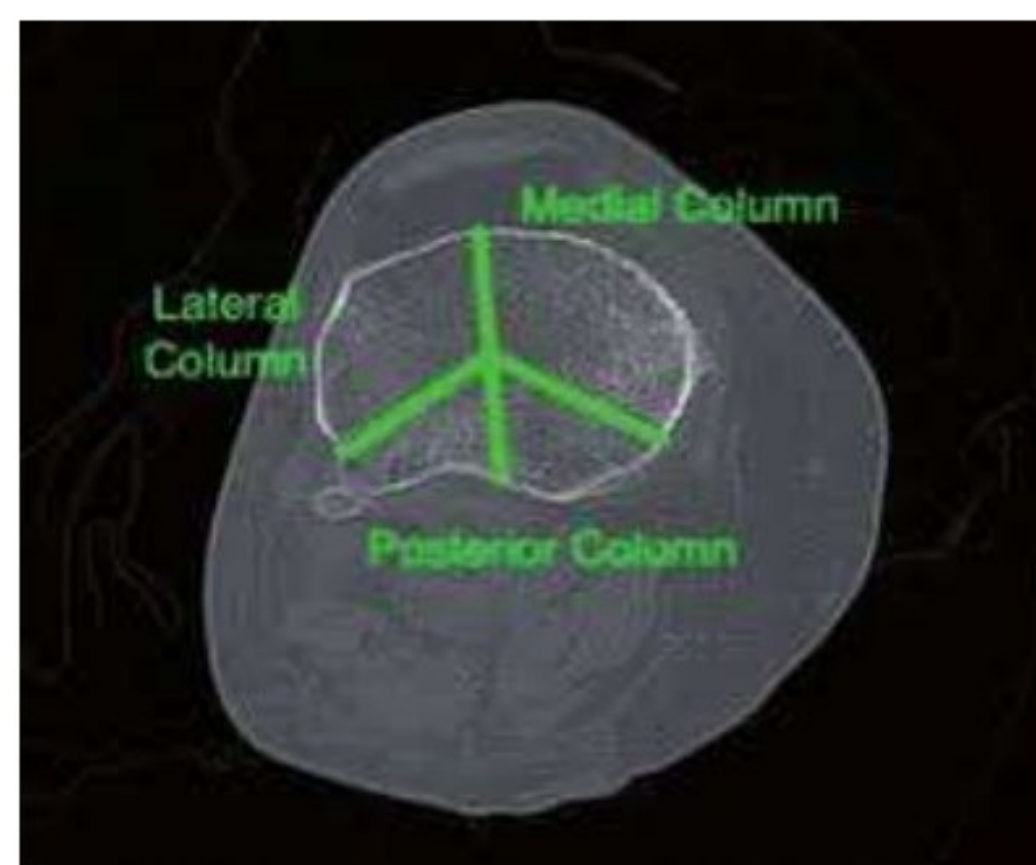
CT image axial section of proximal tibia showing Luo three column classification
